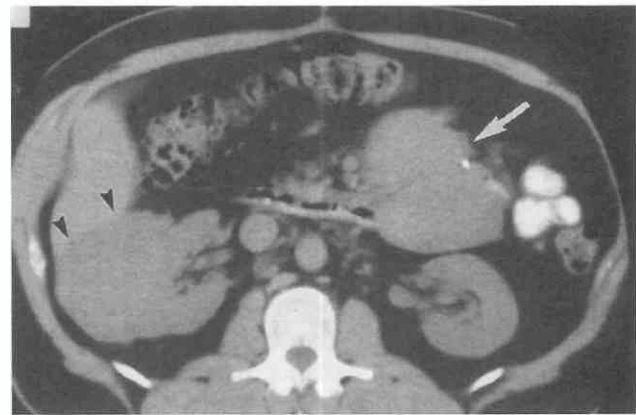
Right perinephric mass (arrowheads) shown on unenhanced CT scan in a patient with non-Hodgkin's lymphoma. A large nodal mass (arrow) involves the small bowel mesentery.
